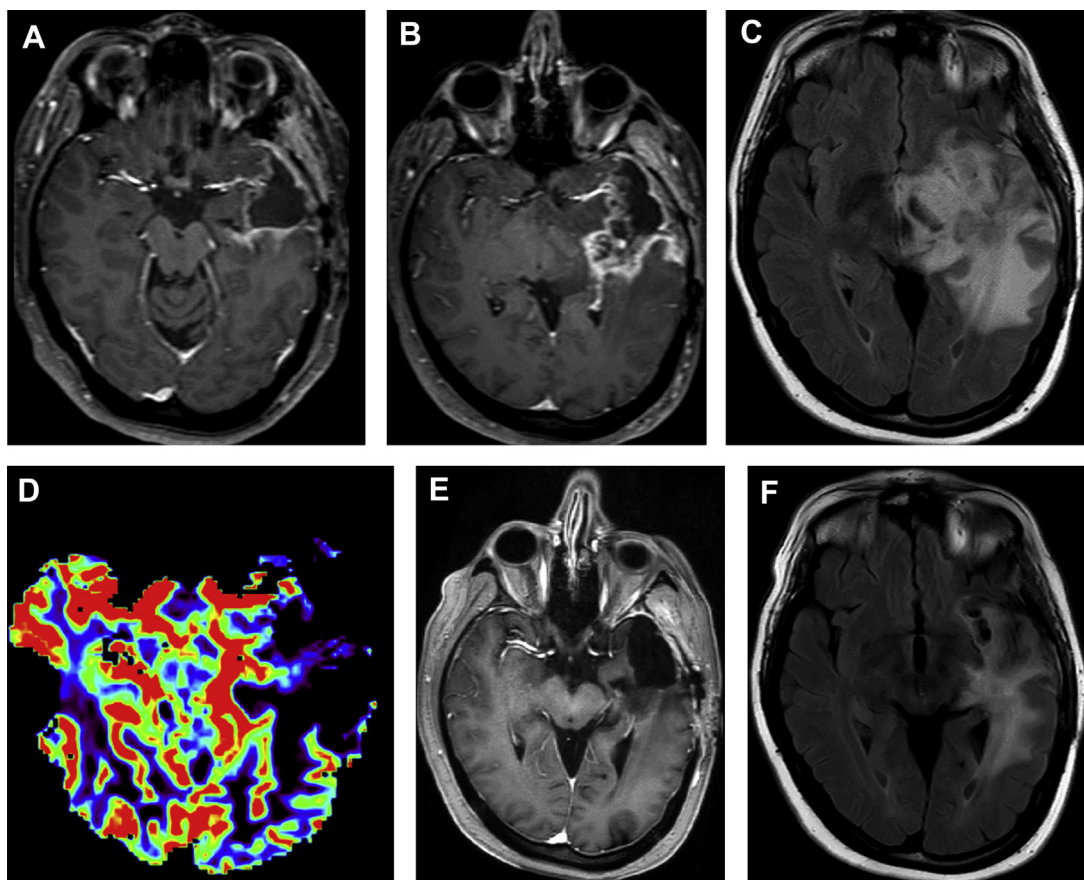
A 41-year-old woman with new-onset spells was found to have a left frontal oligoastrocytoma and secondary left subinsular/temporal lobe glioblastoma (isocitrate dehydrogenase [IDH] mutant, MGMT methylated). MR imaging acquired after gross total resection and chemoradiation therapy with Temodar shows progressive changes from postresection study (A) to 3 months posttreatment examination (B–D) and at 6 months posttreatment (E, F). Postresection MR imaging shows a rim-enhancing cavity in the left temporal lobe (A). Three months after treatment with Temodar, progressive enhancement lining the surgical bed (B) and surrounding hyperintense FLAIR signal (C) is seen but without increased relative cerebral blood volume (rCBV) (D), suggesting a higher likelihood of pseudoprogression than true progression. At 6 months posttreatment, the enhancement (E) and the FLAIR signal (F) have diminished, confirming the initial suspicion of pseudoprogression.
